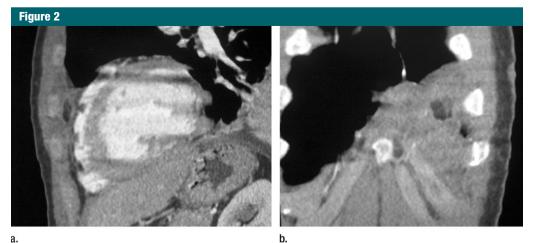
(a) Sagittal reformation CT image shows lack of continuity with infradiaphragmatic or mediastinal fatty tissues. (b) Coronal reformation CT image enables us to confirm lack of continuity with infradiaphragmatic or mediastinal fatty tissues.
